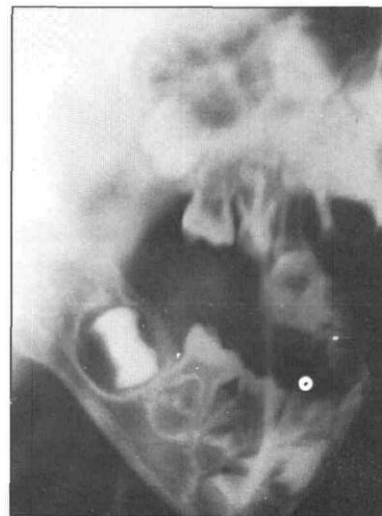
Lateral radiograph of the right mandibular region. Note that the pulp and root show normal appearance, and no evidence of pulp stones.
